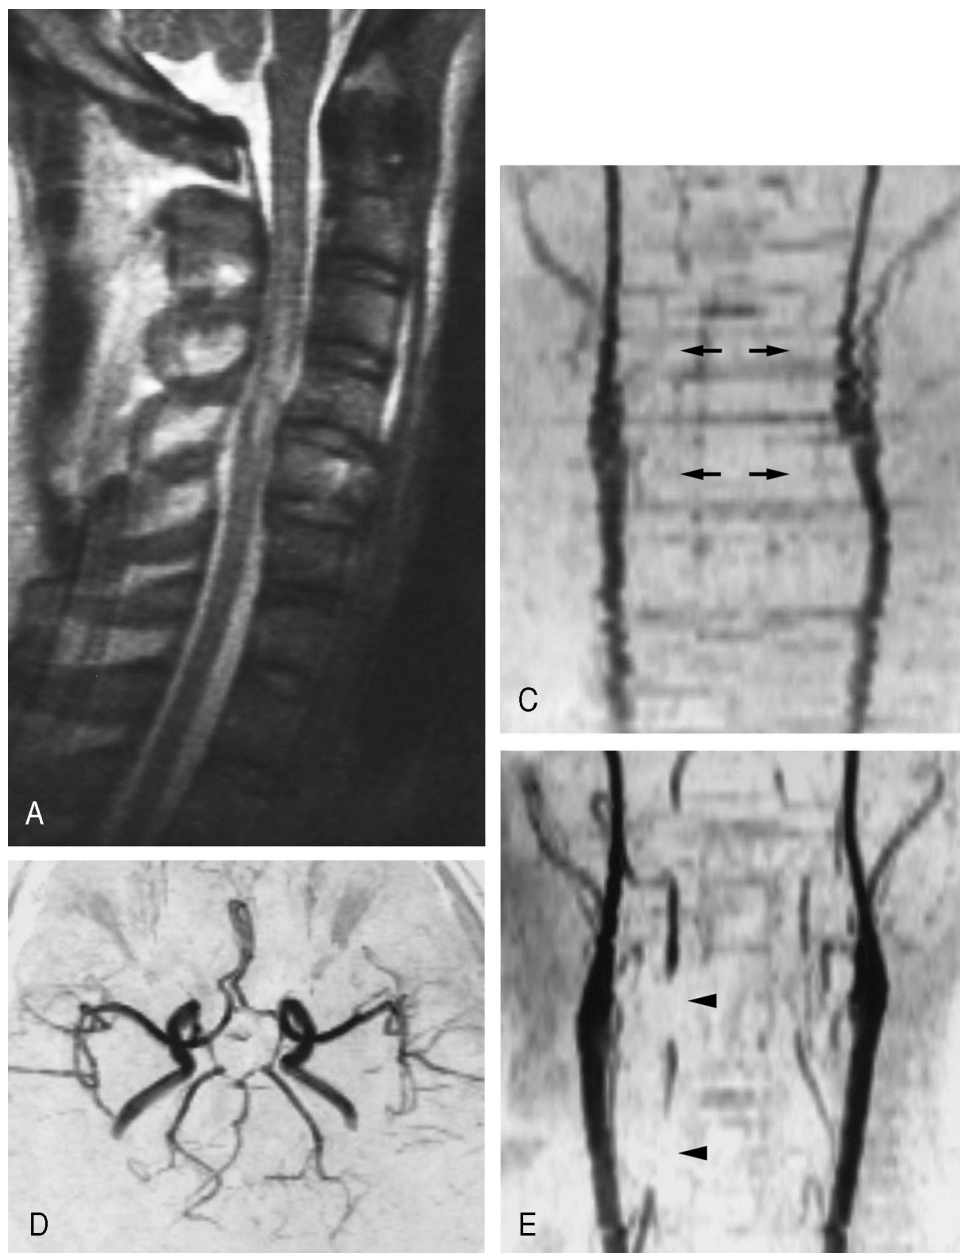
A, Sagittal T2-weighted MRI of a 34-year-old man (patient No. 9) obtained after burst fracture of C5 caused by compressive flexion mechanism shows severe intramedullary lesion. C, Initial MRA shows complete occlusion of the bilateral vertebral artery (arrows). D, Intracranial MRA shows complete configuration of the circle of Willis. E, MRA obtained 1 month after surgical stabilization with instrumentation shows recanalization of the bilateral vertebral artery. Signal of the vertebral artery is partially interrupted by the metal artifact of the implants (arrowheads).
